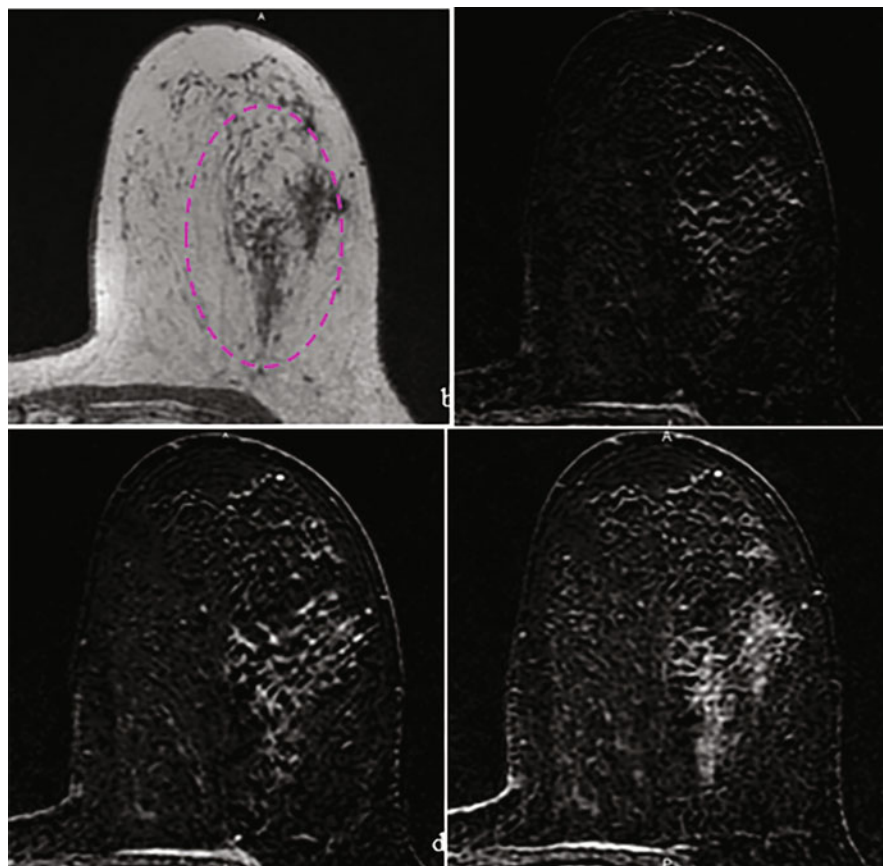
Fifty-four-year old woman with a palpable lump on the left breast. (a) Axial T1-weighted image shows an architectural distortion (circle). (b–d) Subtracted images show a regional non-mass enhancement of low intensity on the first post-contrast dynamic sequence (b) and delayed maximum enhancement (c–d)
